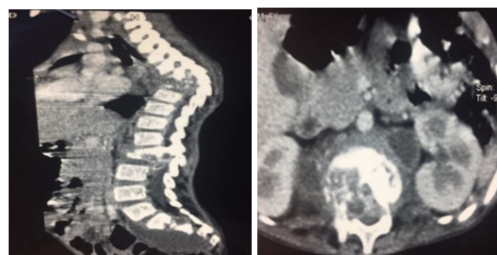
CT scan of the dorsolumbar spine, axial and sagittal section of a child showing vertebral osteolysis of S1, T12 L1 and finally osteolysis of T6 - T7 with vertebral kyphosis.
